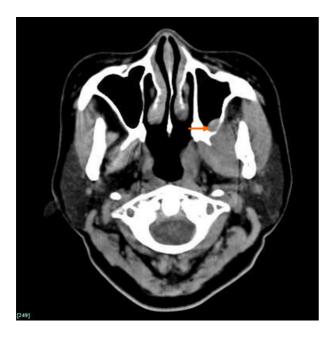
Obvious enlargement of the left side pterygoid muscles appear on computed tomography scanning. The boundary of the lateral and medial pterygoid muscles is obscure. Bone destruction and thickened mucous membrane on the maxilla sinus back wall appear as well (arrow).
